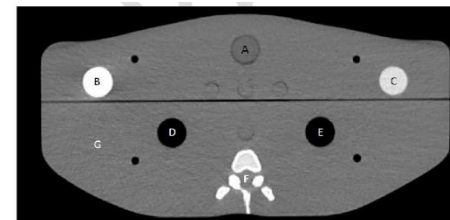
CT image of the shoulder region with electron density plugs: A - water, B - cortical bone, C - trabecular bone, D - lung exhale, E - lung inhale, F - spinal cord, G - soft tissue.
